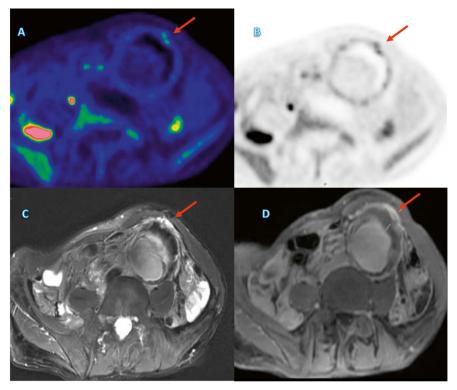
Patient with 63 mm abdominal aortic aneurysm and rapid aneurysm sac expansion (13 mm/year). A+B) Positron emission tomography magnetic resonance imaging (PET MRI) shows focal FDG uptake (arrow) in aneurysm wall C) MRI T2 weighted images shows increased signal indicative of oedema D) Contrast enhanced MRI shows contrast enhancement at the site of FDG hot spot
